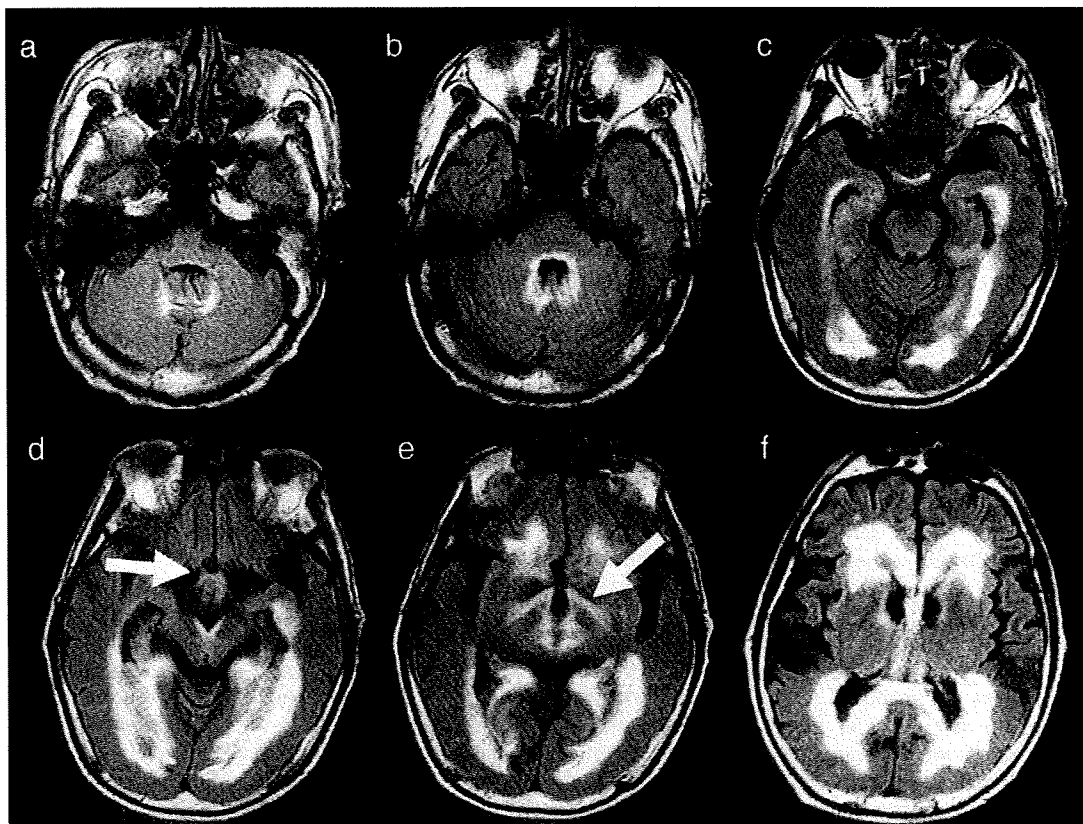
Fluid attenuated inversion recovery (FLAIR) image demonstrated hyperintensities throughout the periventricular parenchyma. The cerebellum (a), pons (b), cerebral white matter (c–f), midbrain (d), optic chiasma (d, arrow), optic tract (e, arrow), hypothalamus (e), and caudate nucleus (f) were involved.
